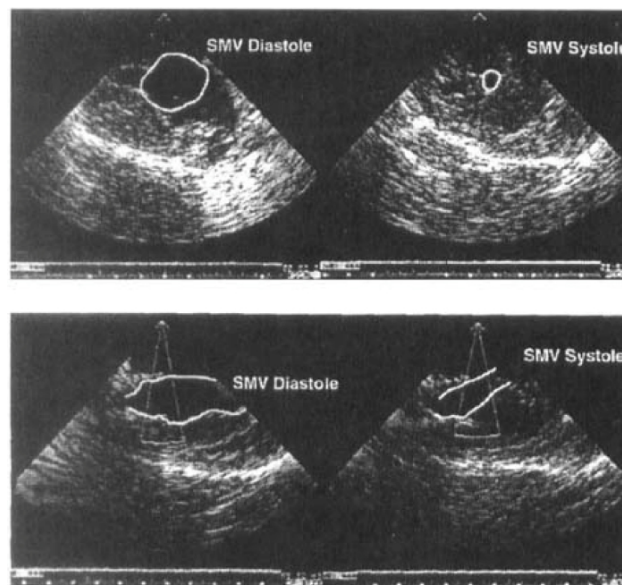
Echocardiographic examination of the skeletal muscle ventricle (SMV) functioning in continuity with the circulation. Top shows short-axis view, and bottom shows long-axis view. Note vigorous contraction between systole and diastole. Reprinted with permission from Reference [3].
